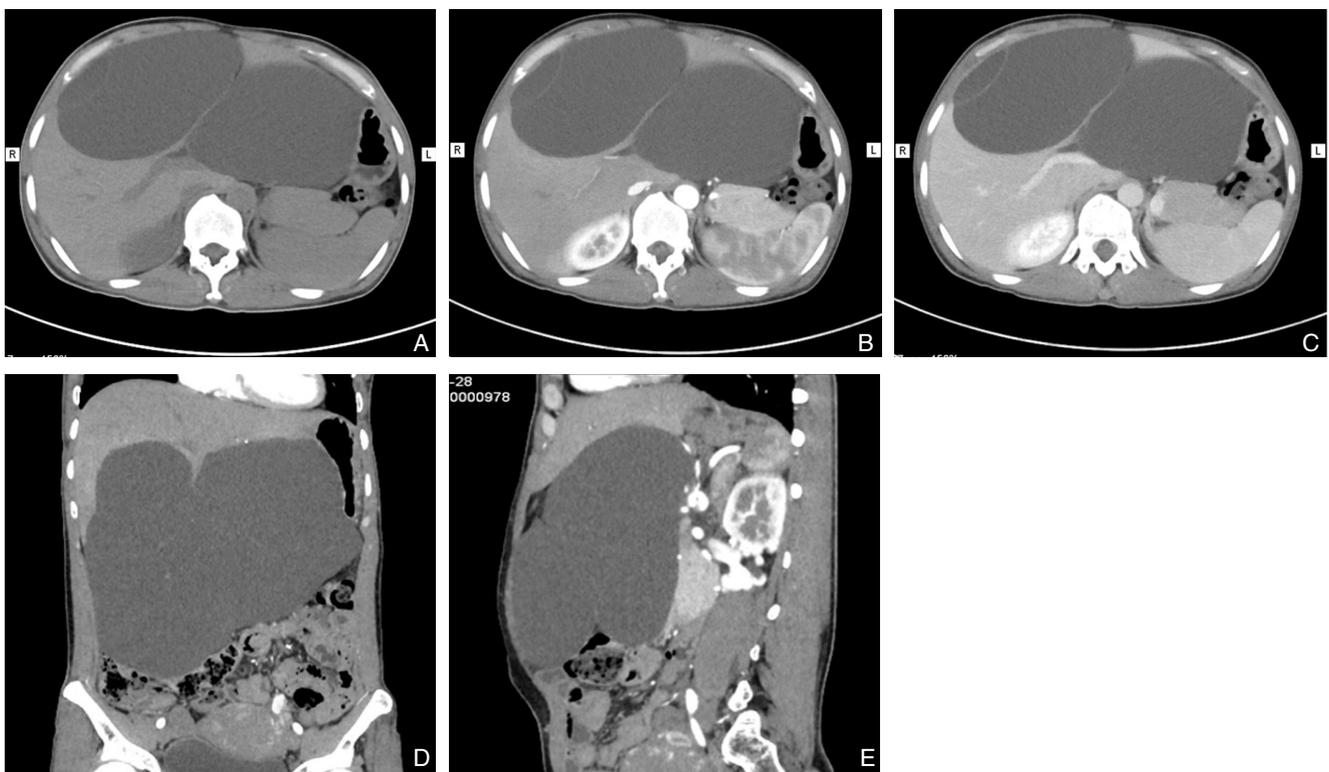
病例 1 术前 CT 图像 A: 平扫; B: 动脉期扫描; C: 门脉期扫描; D: 冠状位像; E: 矢状位像
